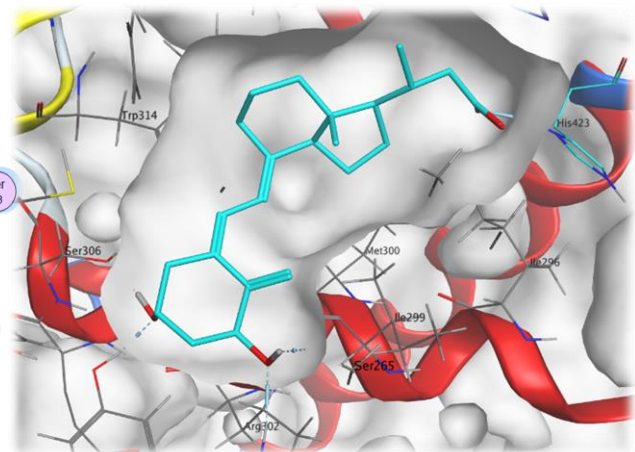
CTA in the binding pocket of zVDR LBD. The two OH residues on the A-ring (lower left, red) are anchored by donor/acceptor interactions with Tyr, Ser, and Arg residues, while the acid function (upper right, red) interacts with histidine.
